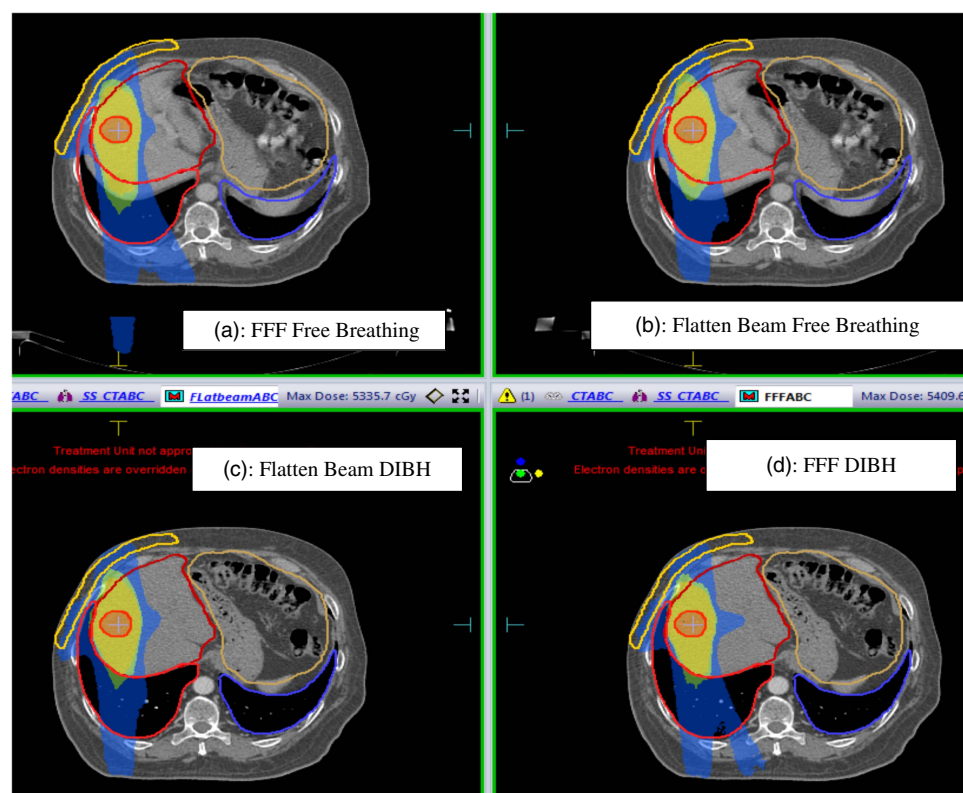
Treatment plans using moderate hypo-fractionated (50 Gy in 10 fractions) for liver SBRT. Panel A: FFF beam in free breathing CT dataset. Panel B: Flatten beam in free breathing CT dataset. Panel C: Flatten beam in DIBH CT dataset. Panel D: FFF beam in DIBH CT dataset. *Abbreviations:* SBRT, stereotactic body radiation therapy; FFF, flattened filter-free.
